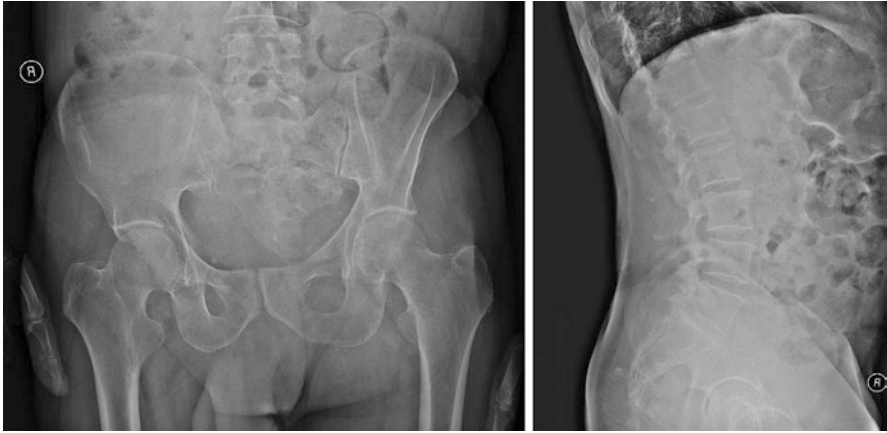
Sacral chordoma. Radiography of the anteroposterior pelvis and lateral lumbosacral vertebra
